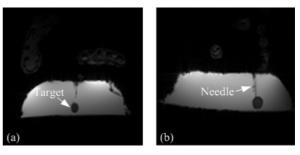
Extract of the images obtained during MRI-guided biopsy with the MPT system: (a) sagittal and (b) transversal orientation relative to the biopsy needle*
